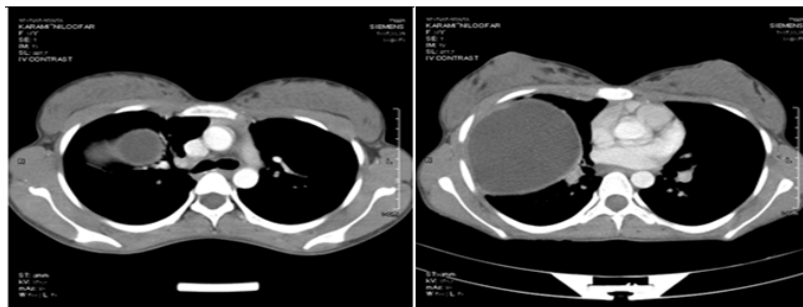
Axial section of thorax and abdomen CT scan
